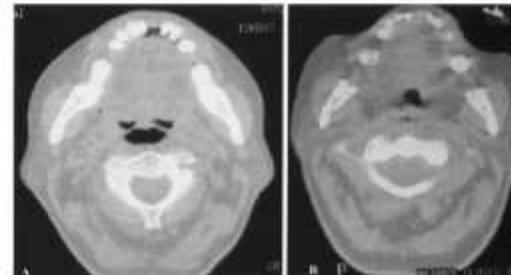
Computed tomogram of the oropharynx in a patient with bulbar amyotrophic lateral sclerosis and a peak cough flow of <math>< 2.7\text{ L/s}</math> (see text). A: Baseline. B: Pharyngeal collapse during exsufflation. (From Reference 46, with permission.)
